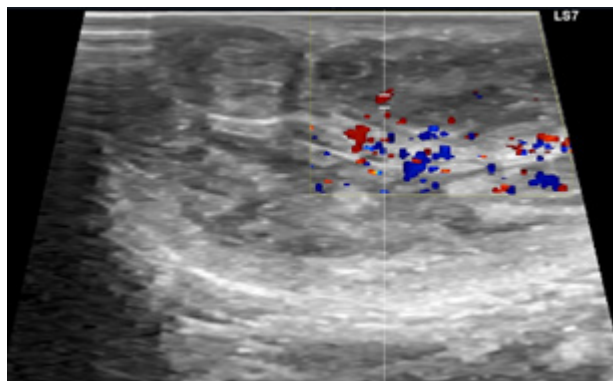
Testicular ultrasonography with doppler of the newborn showing no vascular compromise.
